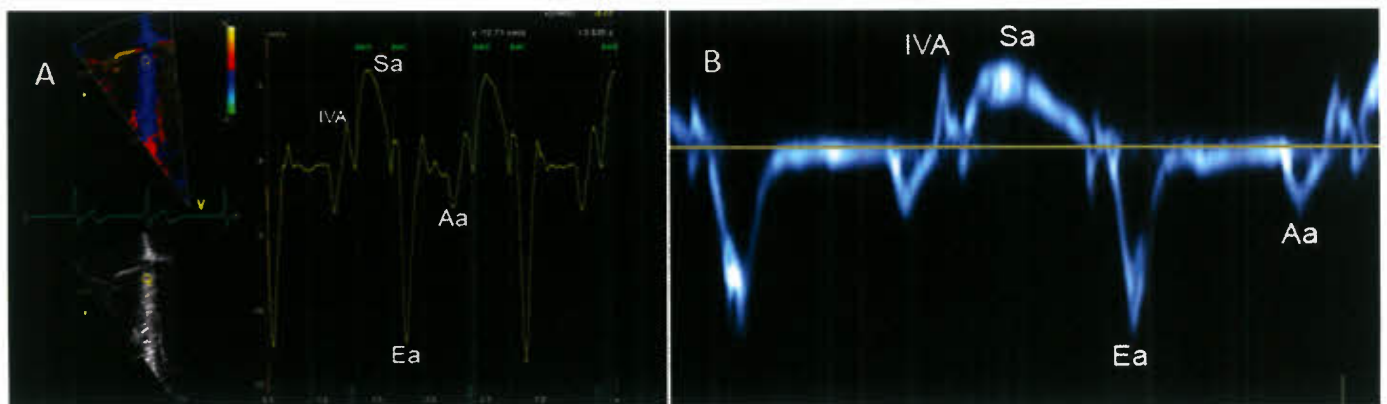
Color and pulsed Doppler in the assessment of diastolic function. Color (panel A) and pulsed (panel B) tissue Doppler sampled at the basal interventricular septum. In the color TDI image, aortic valve opening (AVO) and closure (AVC) are depicted (green lines). Systolic (Sa), early diastolic (E'), and late diastolic (A') waves are seen. Note that tissue velocity directions are a mirror image of atrioventricular valve inflow.
